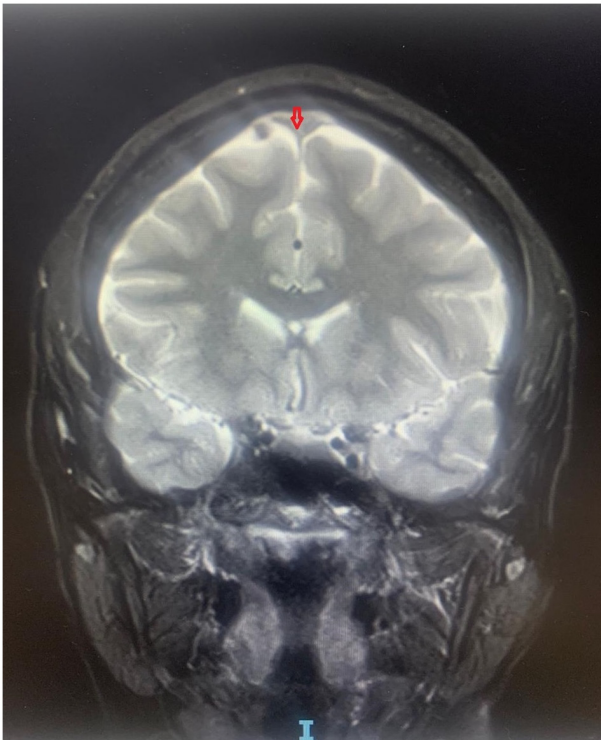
MRI T2-weighted coronal section. The arrow shows loss of flow void in the superior sagittal sinus. Image was obtained in June 2023.
